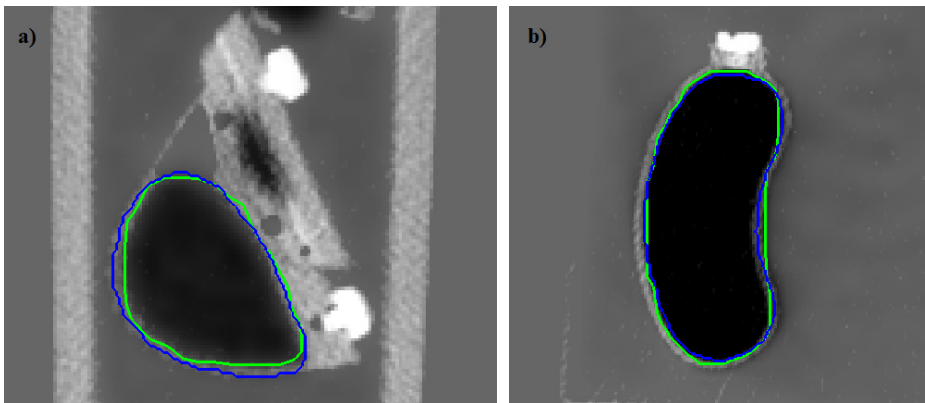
Irregular insert segmentations in PET/CT images: (a) RWg DSC (green line) = 0.981 versus RG DSC (blue line) = 0.964 (b) RWg DSC = 0.962 versus RG DSC = 0.990
